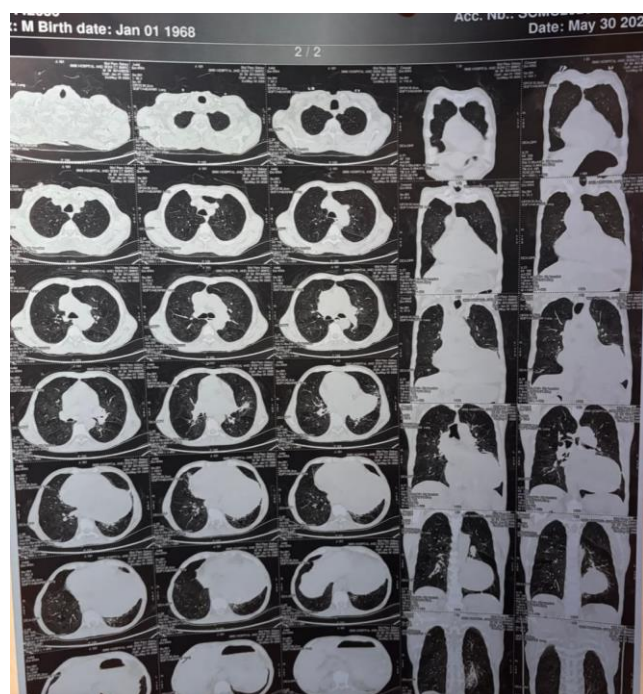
HRCT Chest showing Cardiomegaly with a large isodense lesion lateral to the left ventricle.
